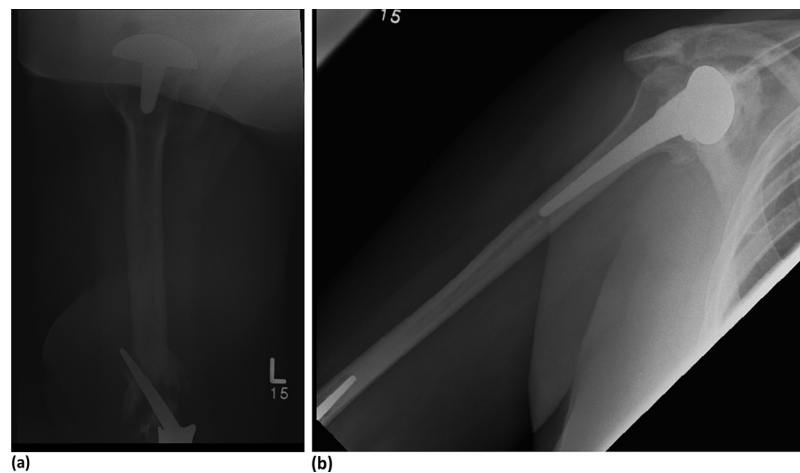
(a) Postoperative axillary lateral view of the shoulder and humerus of a patient who developed loosening and periprosthetic fracture of an ipsilateral total elbow replacement. The presence of resurfacing rather than stemmed replacement for the shoulder diminishes concerns for long stem revision of the humeral component of the elbow replacement. (b) Anteroposterior radiograph of the contralateral humerus of the same patient. A “vacant segment” stress riser is seen between the tips of the stemmed shoulder and the elbow prostheses.
